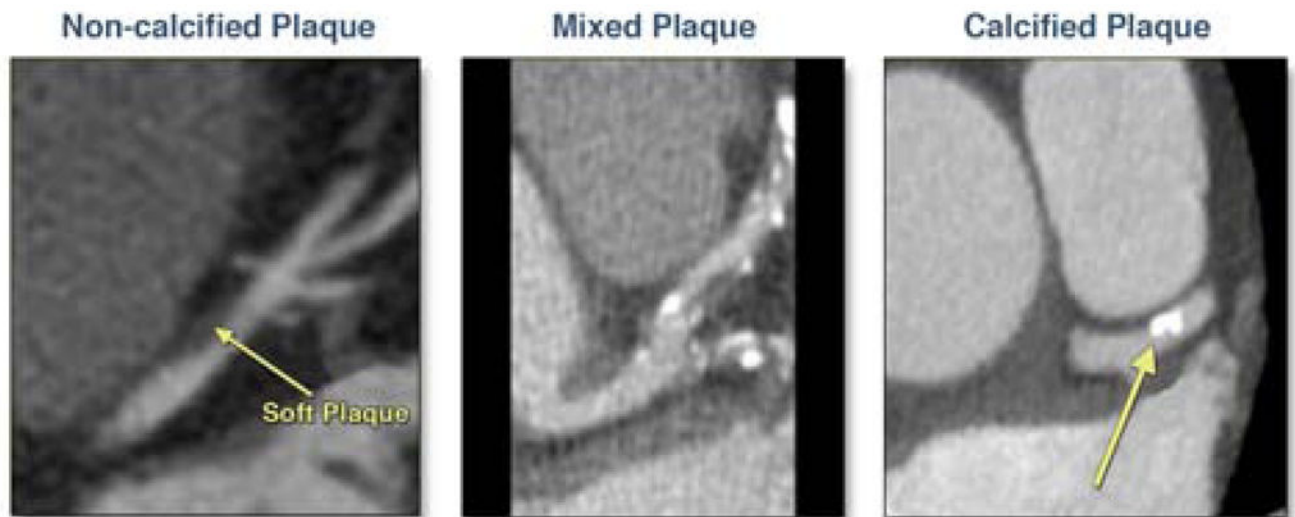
Coronary Plaques Detected by Coronary CTA in the Multicenter AIDS Cohort Study (55)
